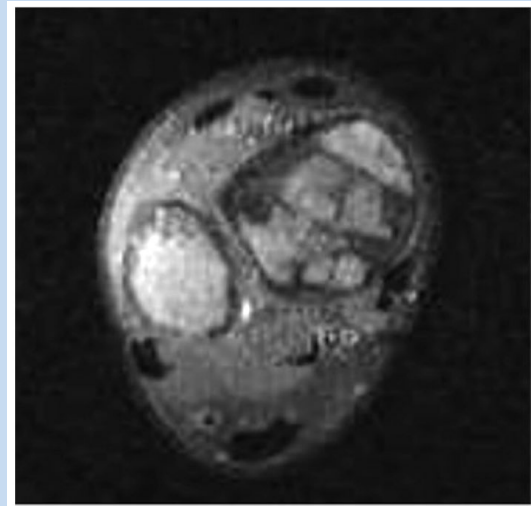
Multicentric sarcoma: T2-weighted axial magnetic resonance imaging of the distal tibia-fibula demonstrating sarcoma-related bone marrow lesions.
